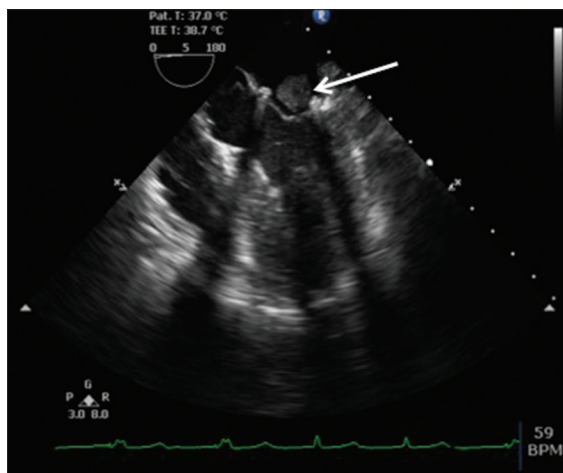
Intraoperative transesophageal echocardiography shows a hyperechoic structure adhering to the mitral annulus (white arrow)
